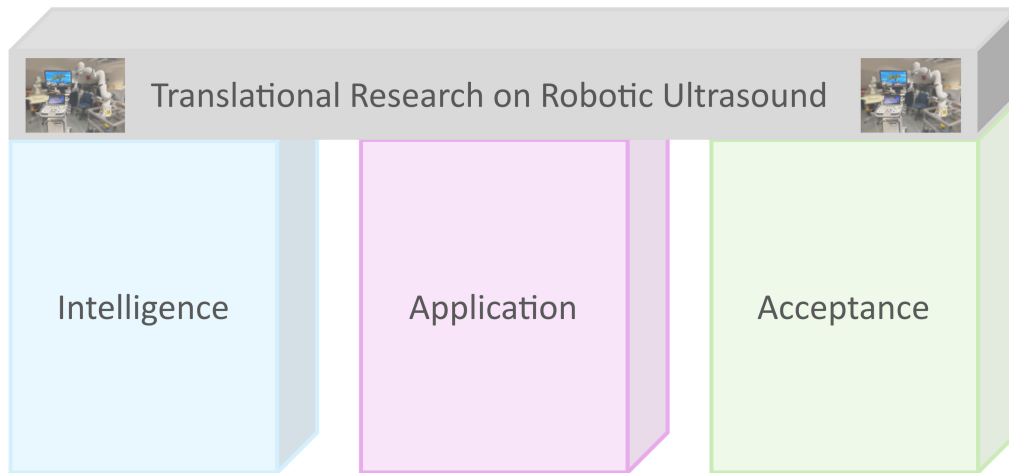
The three pillars for successful translational research on robotic ultrasound: intelligence, application, and acceptance.
